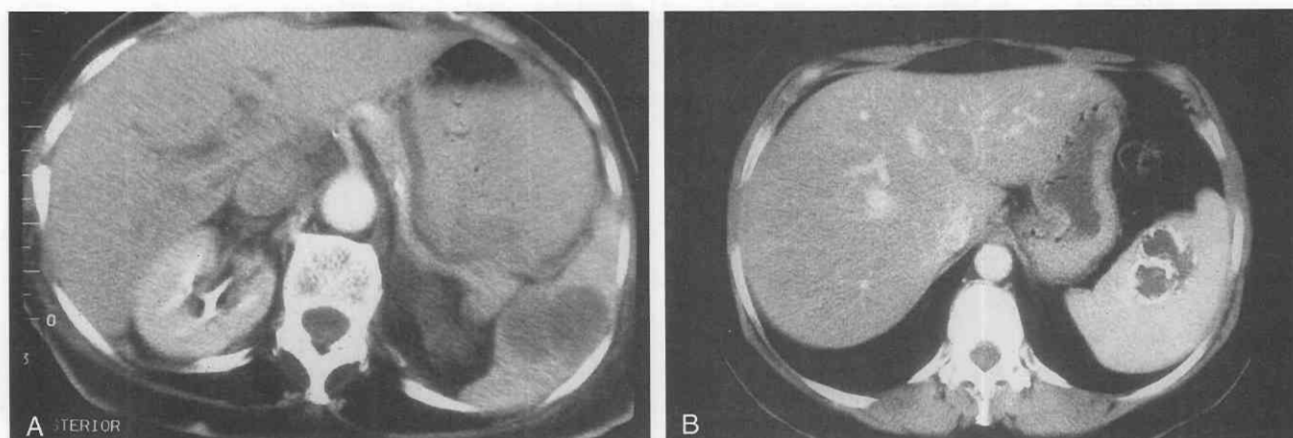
CT scans showing splenic cysts. A, Splenic cyst with septations. B, Splenic cyst with peripheral calcifications.
